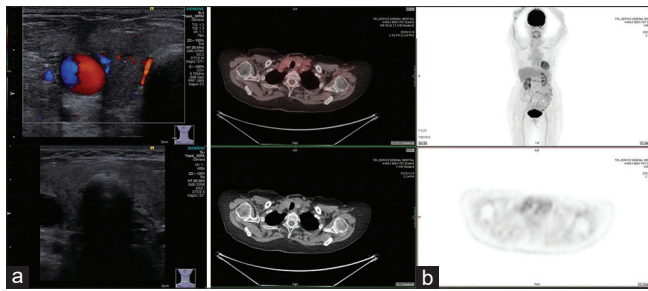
(a) After three cycles of rituximab, cyclophosphamide, vincristine, prednisone, the primary thyroid lymphoma disappears on the color Doppler and gray-scale ultrasonography. (b) Complete remission of the primary thyroid lymphoma is confirmed on the positron emission tomography computed tomography (left) and whole-body positron emission tomography scan (right) after three cycles of rituximab, cyclophosphamide, vincristine, prednisone regimen
